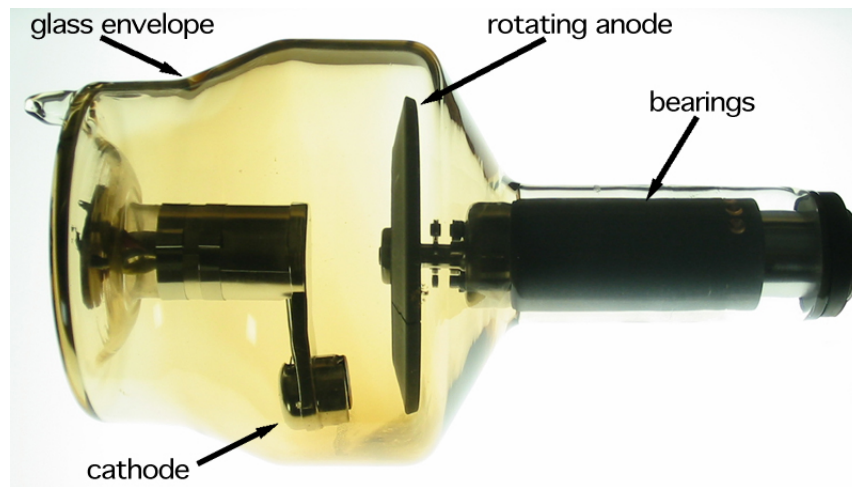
A rotating anode x-ray tube is shown with key parts labelled. [58] [Reproduced from Wikimedia by Daniel W. Rickey, CC BY-SA 3.0]
